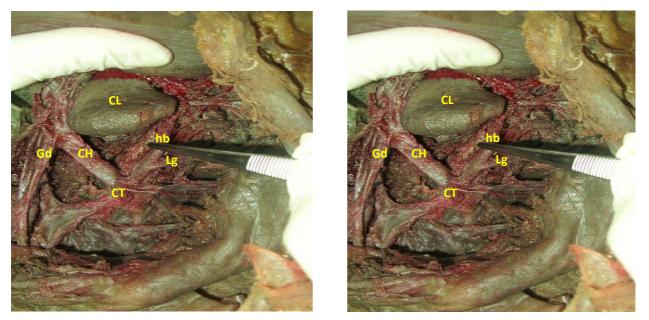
(left).- Anterior view: Lesser omentum has been removed and liver elevated. Celiac trunk (CT) branching pattern shows left gastric artery (Lg) give an additional branch hepatic branch (hb) to liver which runs to the left side of caudate lobe (CL). Common hepatic artery (CH) gives Gastro duodenal artery (Gd) descending inferiorly.
